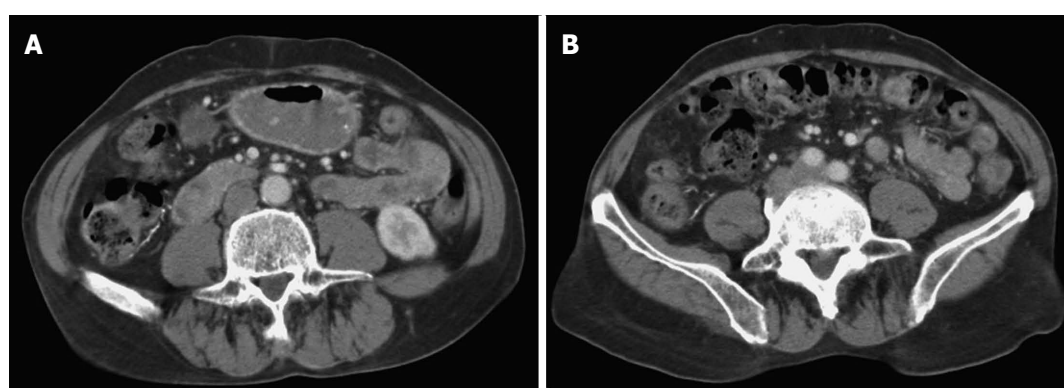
Intravenous contrast enhanced computed tomography of an asymptomatic patient. A 72-year-old male has not experienced any significant abdominal symptoms. A: Computed tomography study showed calcifications at mesenteric veins; B: There was thickening of the wall of the cecum and ascending colon with pericolic stranding, which may indicate active disease.
